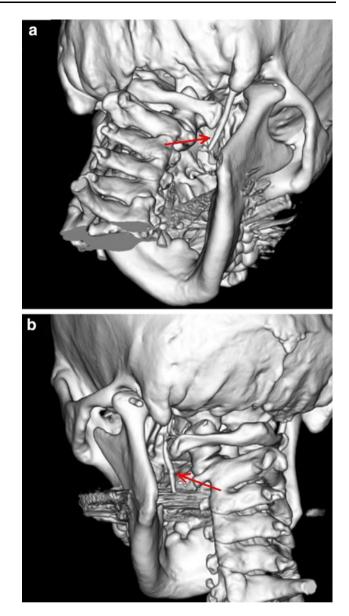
Three-dimensional computed tomography of the styloid process: the length of the right side is $35.1 \text{ mm}(\mathbf{a})$ and that of the left side is $29.6 \text{ mm}(\mathbf{b})$
